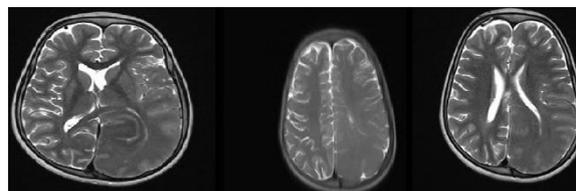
MRI images suggestive of focal hamartomatous overgrowth of left occipital lobe, parietal lobe and superior part of temporal lobe with broad gyri and shallow sulci
